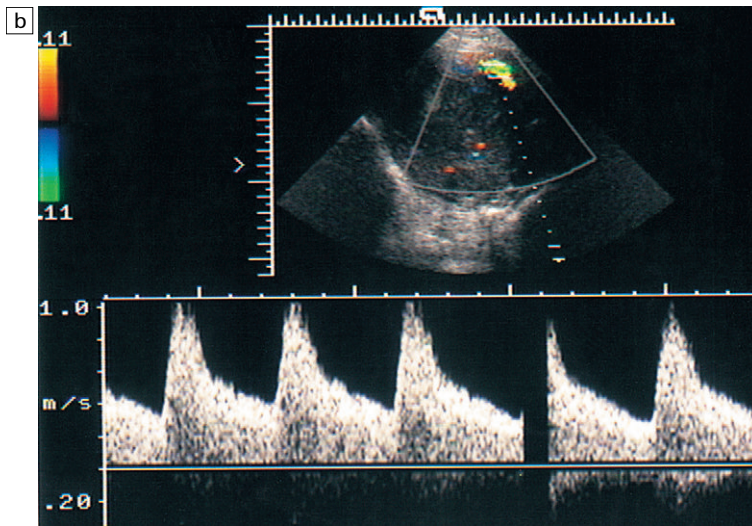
Doppler spectrum of uterine artery flow in postmenopausal uterus with uterine fibroids. No evidence of increase in blood flow velocities, particularly in diastole.
